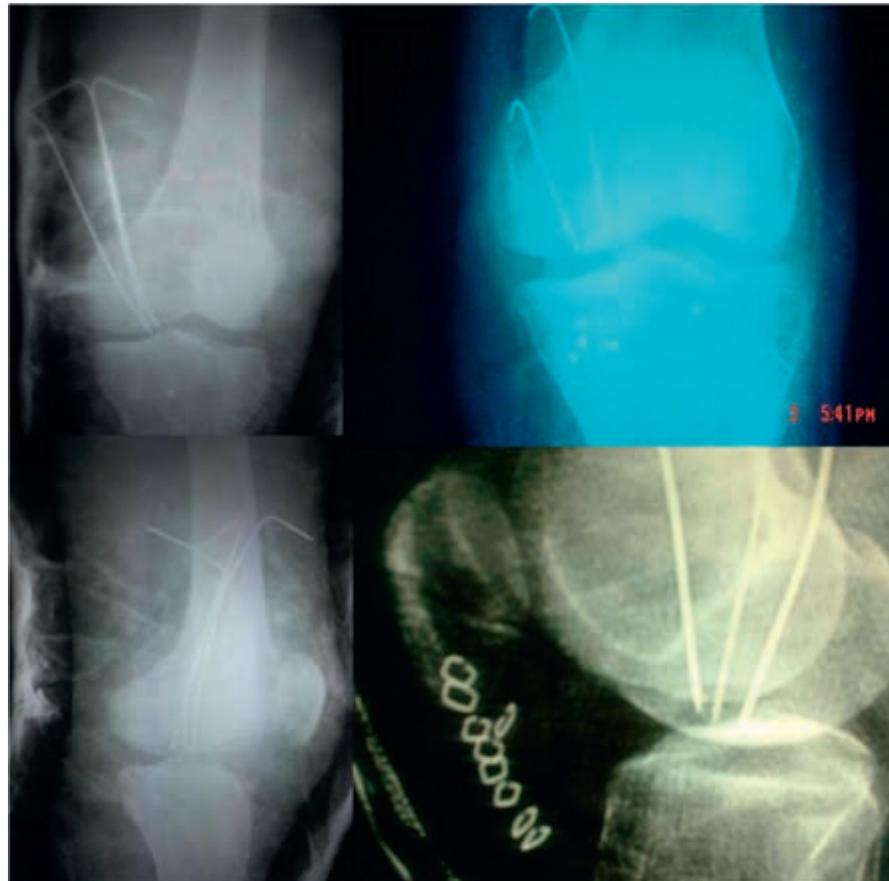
Postoperative AP and lateral X-rays of knee showing fixation of the OCF with multiple K wires.
